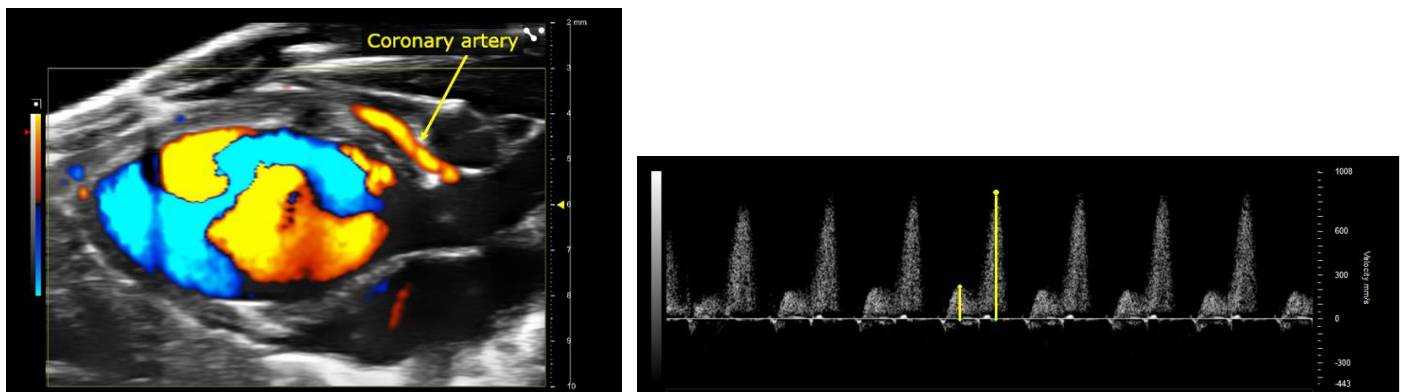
Color EKV of the coronary artery (left) and PW Doppler waveform of the coronary artery (right).
